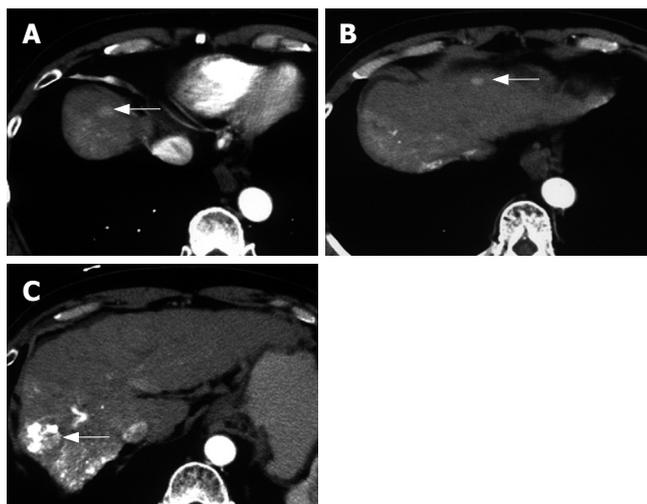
Contrast-enhanced CT at the time of the diagnosis of brain metastases shows multiple hypervascular HCCs (arrows) (A, B, C). Lipiodol retention in the main tumor is seen (C).
